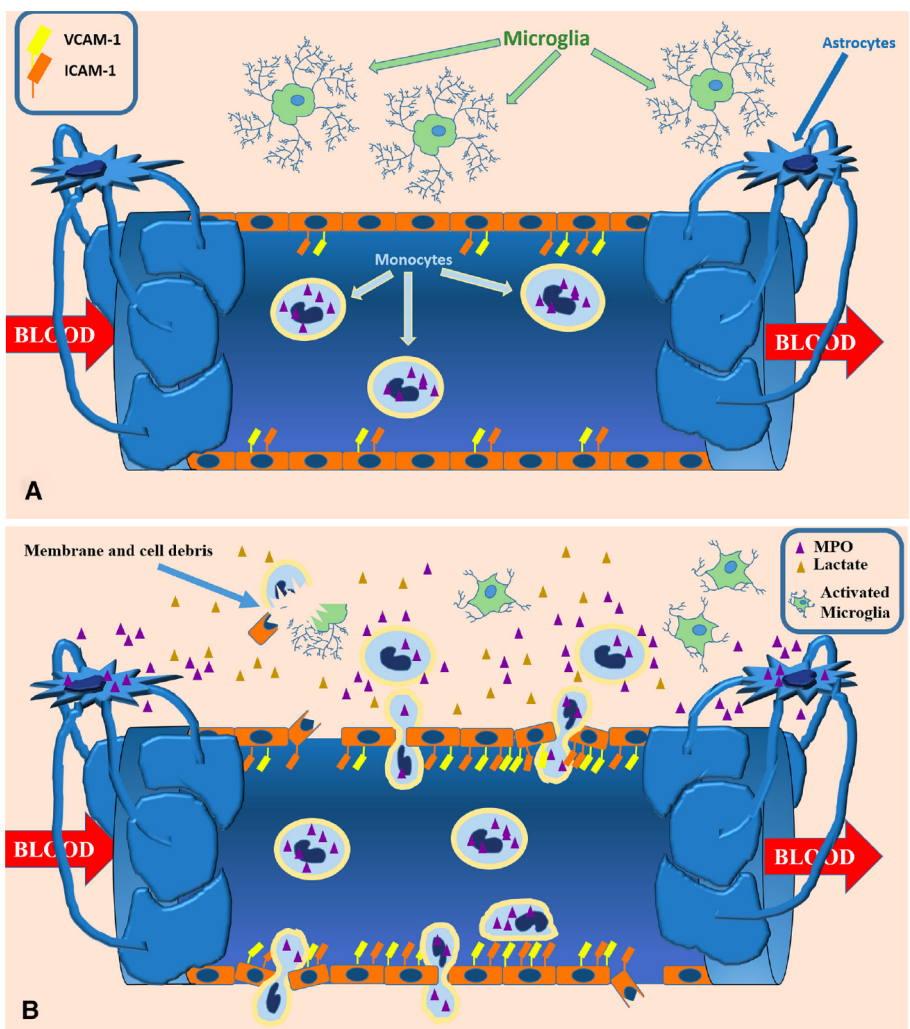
Normal working of the immune system (A) followed by its alteration in MS (B). (Figure 1 from [128]; original caption: *Main neuroinflammatory mechanisms probed by MRI. Modifications of the neurovascular unit include alterations of the BBB permeability, associated with overexpression of adhesion molecules, which induce blood-borne monocytes to arrest and crawl along the endothelium, crossing it by diapedesis along loosened intercellular junctions. Macrophage and microglia activation results in increased MPO activity and lactate accumulation in the interstitium, along with the presence of cellular debris resulting from cell damage due to oxidative and excitotoxic phenomena.* Article [128] is distributed under the terms of the Creative Commons Attribution 4.0 International License (<http://creativecommons.org/licenses/by/4.0>), by Springer Publications, Ltd.: Clinical and translational imaging, 6(5):475-489, copyright © 2015.)
